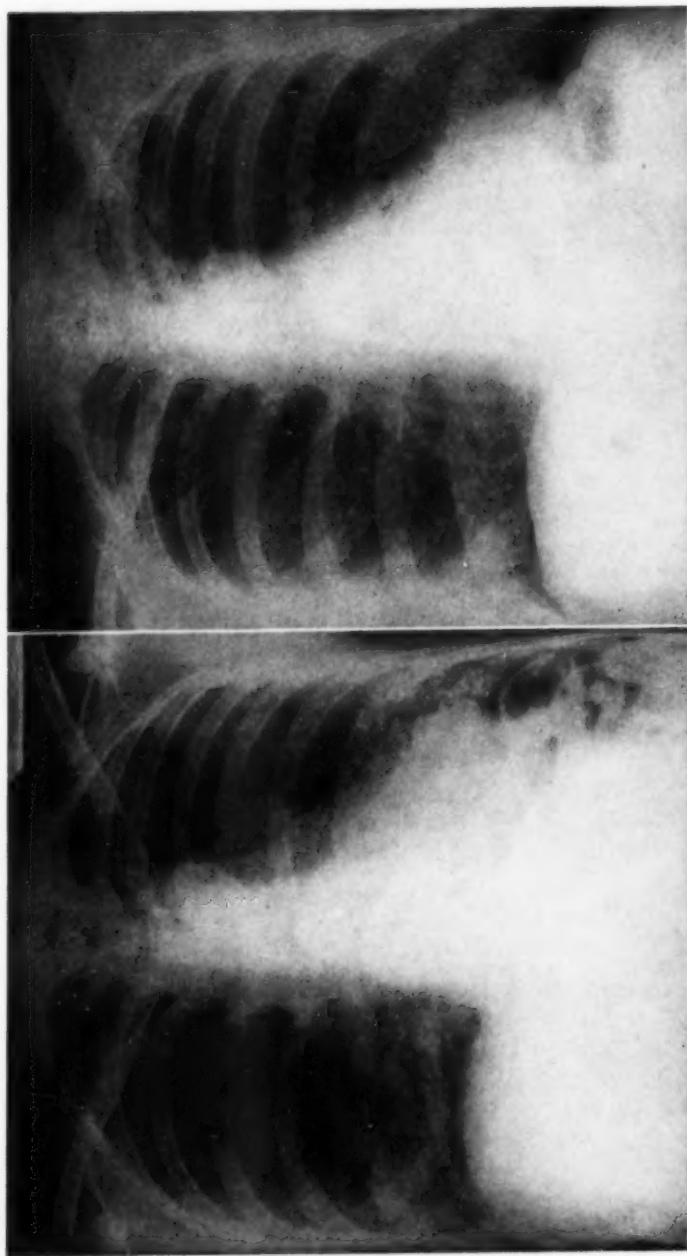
A. Standard chest x-ray on the forty-first hospital day, showing virtual disappearance of the rarefaction in the right lower lobe. B. Chest x-ray on May 9, after four weeks at home, showing a scar in the right lower lobe and considerable clearing of the diffuse nodular infiltration in all lobes of the lung.
